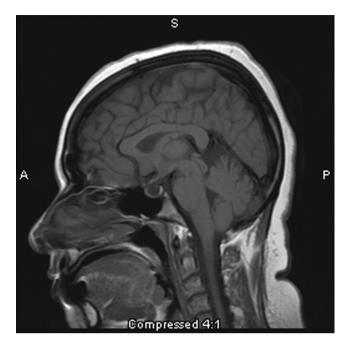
Sagittal MRI demonstrating an "empty sella". A large sella without readily apparent pituitary tissue is a common finding indicative of elevated intracranial pressure. (Image courtesy of Neil Miller).
